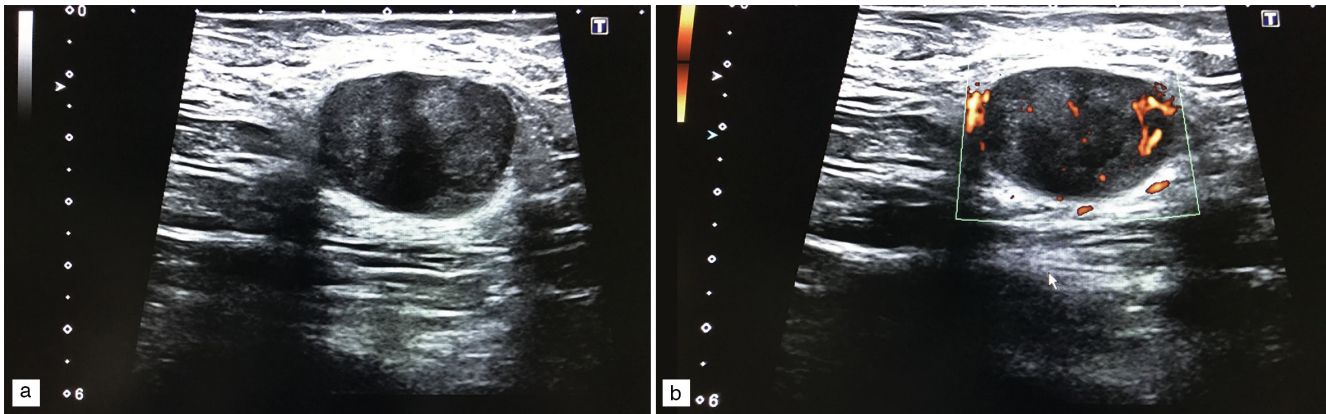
Human epidermal growth factor receptor 2 (+), Invasive ductal carcinoma in a 45-year-old woman with ipsilateral axillary lymph node metastasis. (a) B-mode sonogram shows an enlarged, round shaped lymph node with loss of the central fatty hilum in the left axillary fossa. (b) Power Doppler Sonogram reveals increased peripheral blood flow signals
